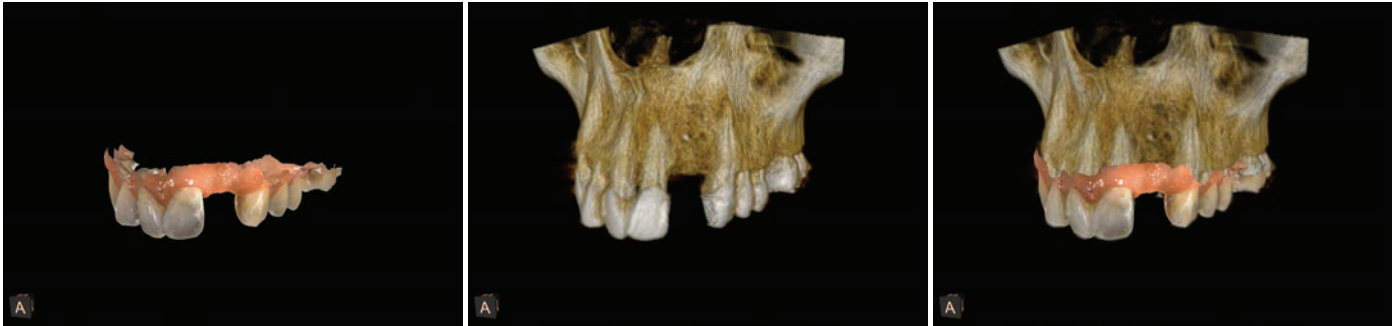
Using virtual treatment planning software, the data from the CBCT scan and digital impression are merged together.
